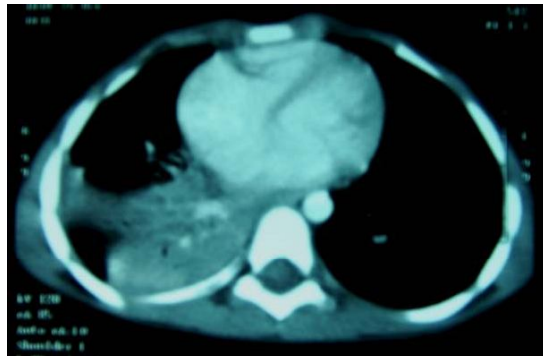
Post contrast CT showing drowned lung appearance and mucus bronchogram sign
